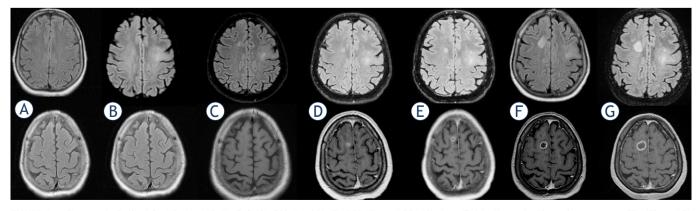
MRI scans in Patient 3 at 0 (A), 465 (B), 742 (C), 790 (D), 811 (E), 825 (F) and 854 (G) days (fluid attenuated inversion recovery [FLAIR] and T1 with gadolinium sequences).
